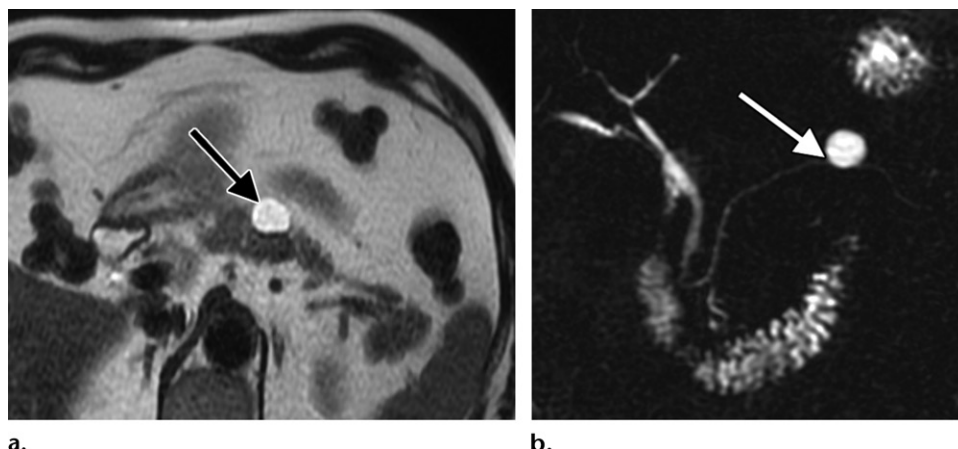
Pancreatic cystic lesion found at US in a 64-year-old woman. (a) Axial SSFSE T2-weighted MR image shows a 2.0-cm cystic lesion (arrow) in the pancreatic body. (b) Coronal 2D single-shot MRCP image shows the lesion (arrow) adjacent to the main pancreatic duct; the lesion is likely an intraductal papillary mucinous neoplasm.
